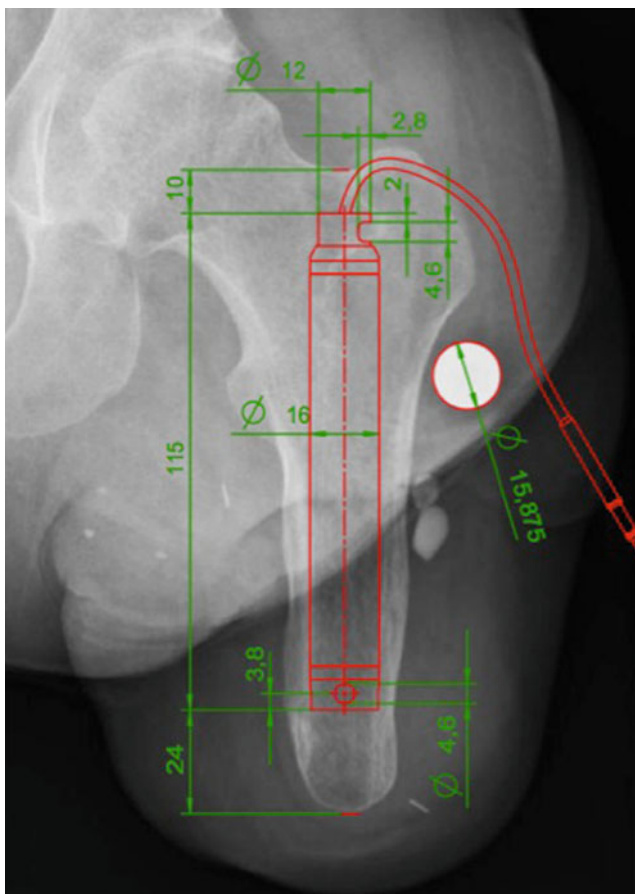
Preoperative X-ray with the planned femoral lengthening rod superimposed
